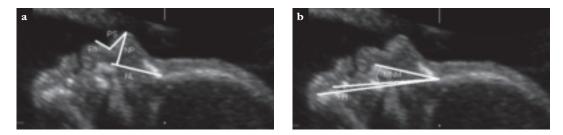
Ultrasound images of the fetal face showing nose length (NL), nose protrusion (NP), philtrum length (Ph) and pronasale-subnasale distance (PS) (a) and facial height (FH) and maxilla-nasion-mandible angle (MNM) (b).
